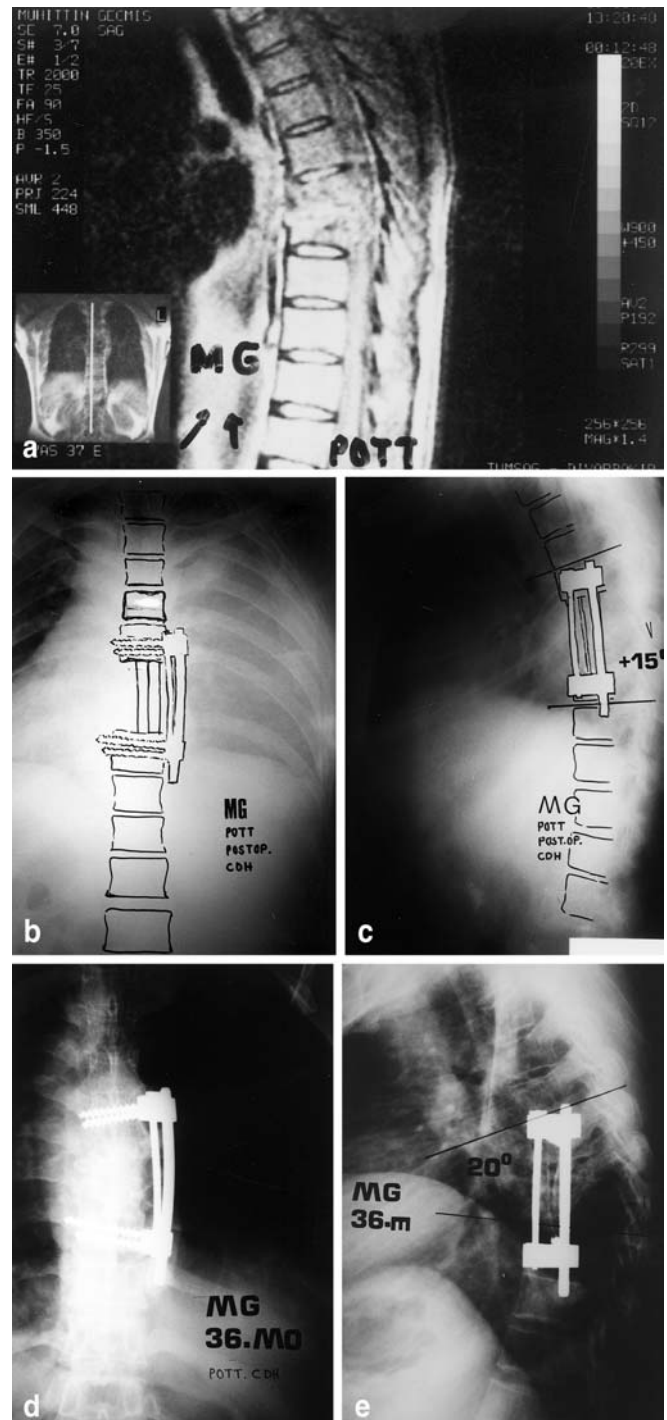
A 37-year-old man (M.G.) with Pott's disease in the T8–9 vertebrae. Two mobile segments were instrumented with anterior Cotrel-Dubousset-Hopf (CDH) instrumentation, and a 66.7% correction rate and complete neurologic impairment was obtained after anterior radical debridement and strut grafting. There was a 5° loss of correction in local kyphosis angle at the last visit. Preoperative sagittal MR image (A) and postoperative posteroanterior (B) and lateral (C) radiographs, and 36-month control posteroanterior (D) and lateral (E) radiographs
